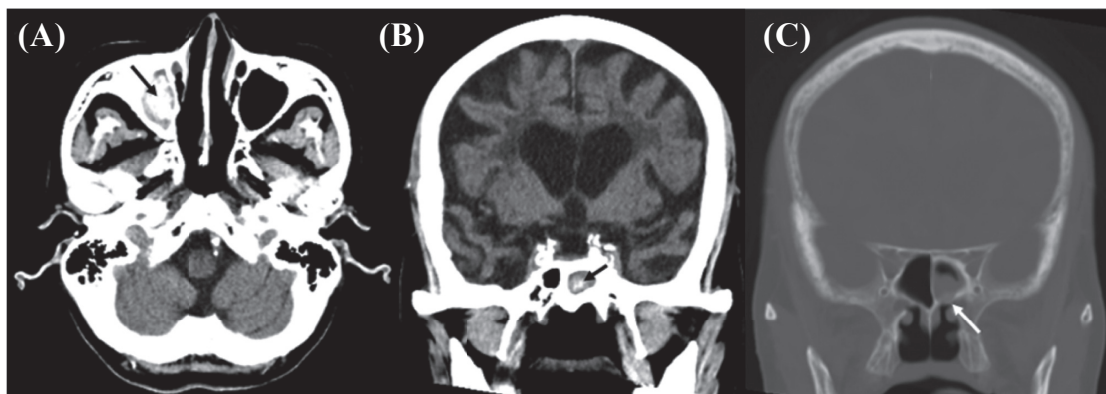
(A) Axial and (B) coronal computed tomography (CT) shows heterogeneous lesions with calcification in the right maxillary sinus and the left sphenoid sinus (black arrow). (C) Axial CT of the bone window shows the left sphenoid bony erosion (white arrow).
